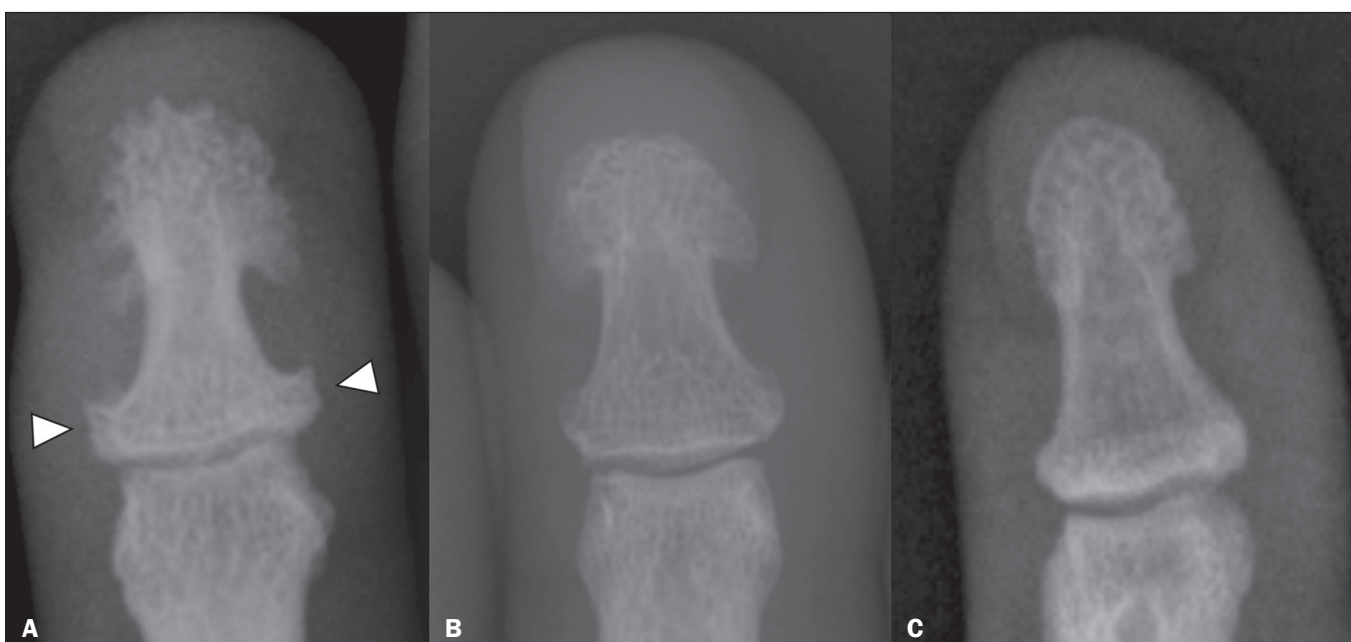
A: Radiograph of the distal phalanx of the hand of a patient with acromegaly, showing hypertrophy of the terminal tuft, with a spade-like appearance, together with widening of the base of the phalanx (arrowheads). B: Radiograph of the distal phalanx with a spade-like appearance but without significant widening of the base, suggestive of a normal variant. C: Radiograph of the distal phalanx in a healthy patient, showing no alterations.
